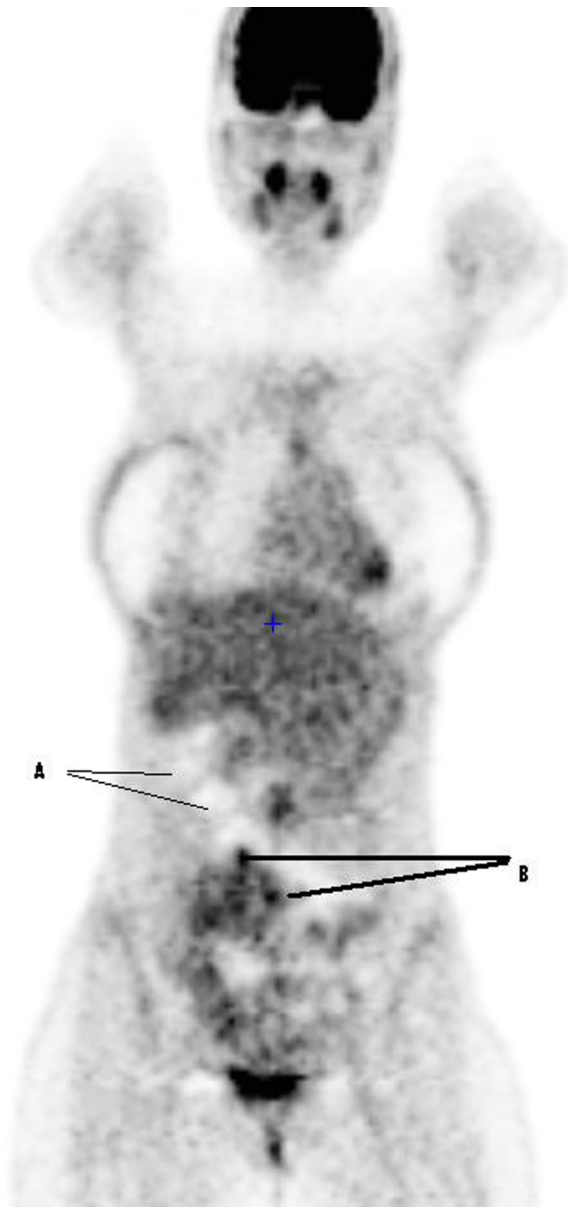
Coronal Pet/CT image. A: nodules without metabolic activity; B: nodules with a weak hypermetabolic activity.
